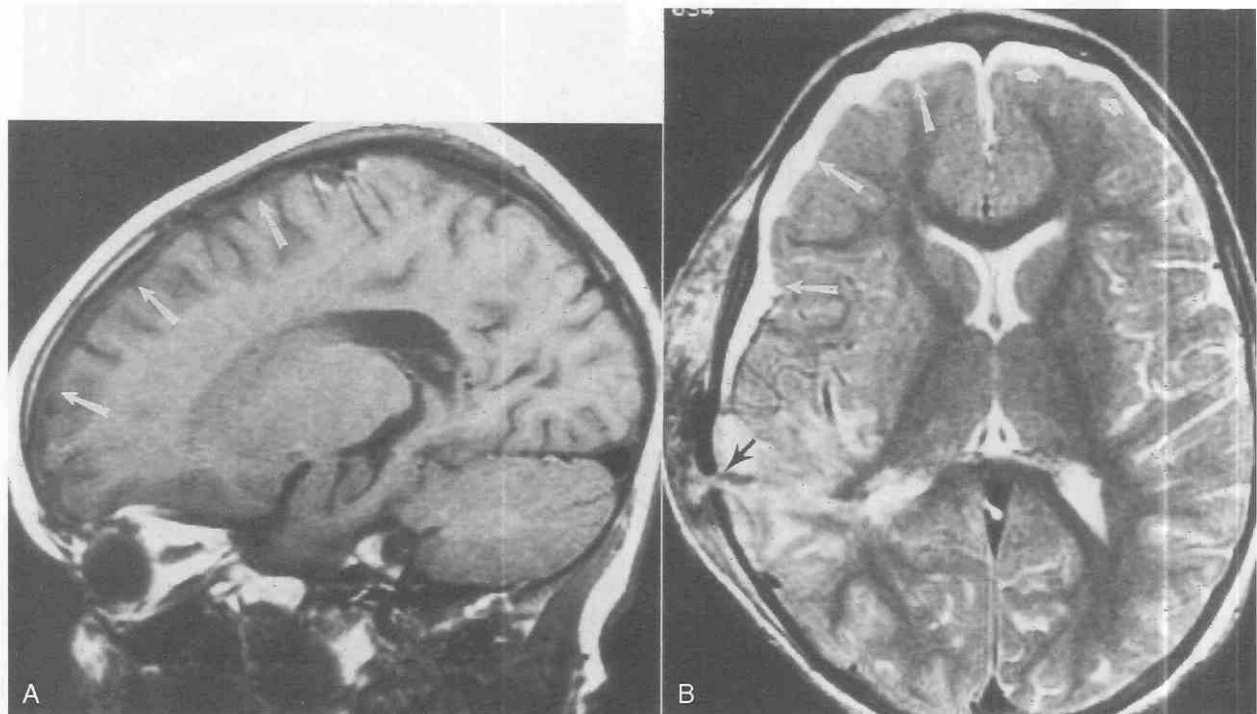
A and B, Same case as shown in Figure 6-23. Sagittal T1-weighted (500/15) and axial fast spin-echo/T2-weighted (3500/108) MR images show cerebrospinal fluid hygroma over right frontotemporoparietal convexity (arrows). The small left frontal convexity hygroma not evident on the CT scan is well visualized on the MRI study (small arrows). Note the right temporal lobe contusion and herniation of the temporal lobe through the temporal bone fracture (black arrow).
